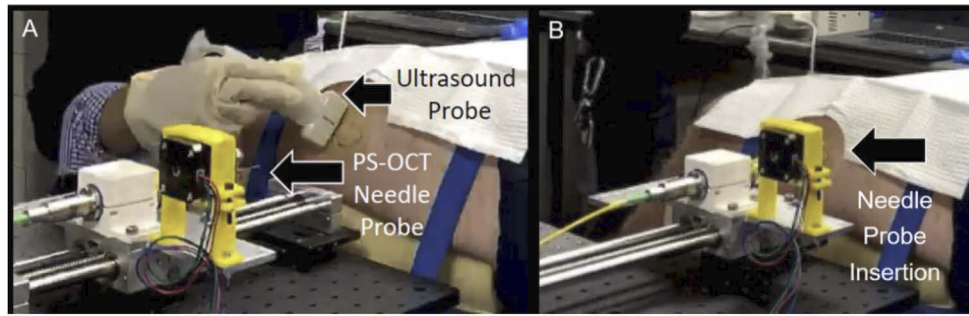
A) Photo of system/sample arrangement with the leg strapped onto the bench and the area where the needle is to be inserted into the leg sterilized with iodine. An ultrasound probe is used to visualize subsurface tissue. B) The needle probe is attached to the combined translation and rotation stage and inserted into the thigh muscle.
